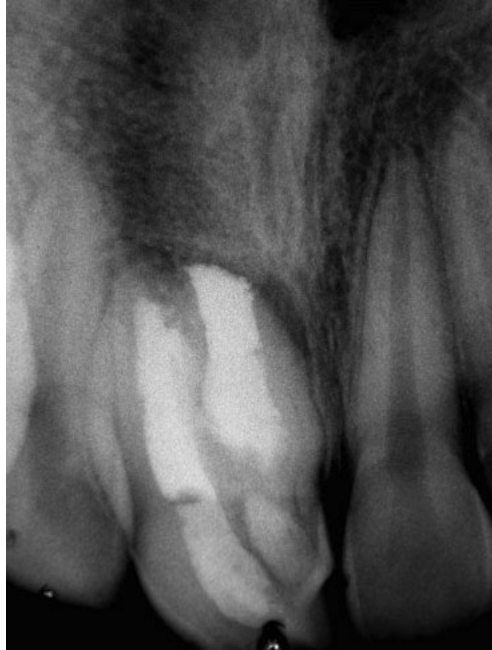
Periapical radiograph immediately after main canal filling and calcium hydroxide treatment for pseudo canal apexification.
